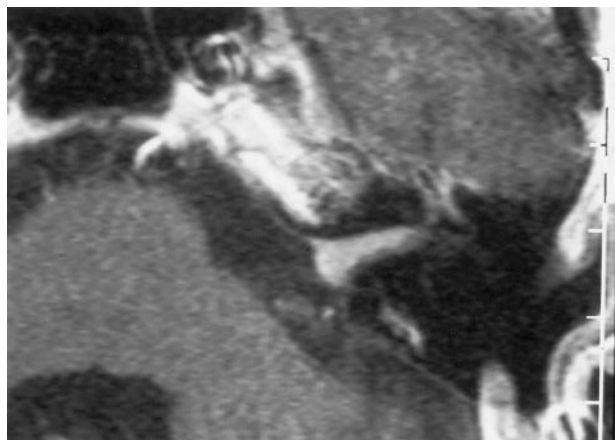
Case 1: 66-year-old man with an entirely intracanalicular meningioma. Contrast-enhanced axial T1-weighted MR image (450/14 [TR/TE]) reveals a homogeneously enhancing mass filling the IAC.
